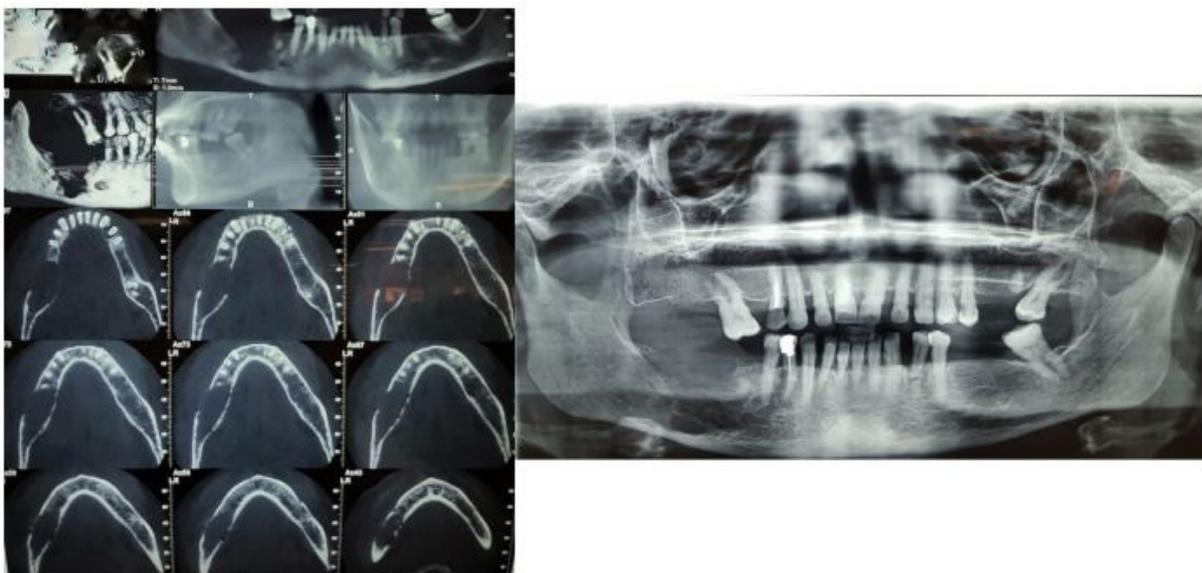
Cone Beam Computed Tomography of Lesion
